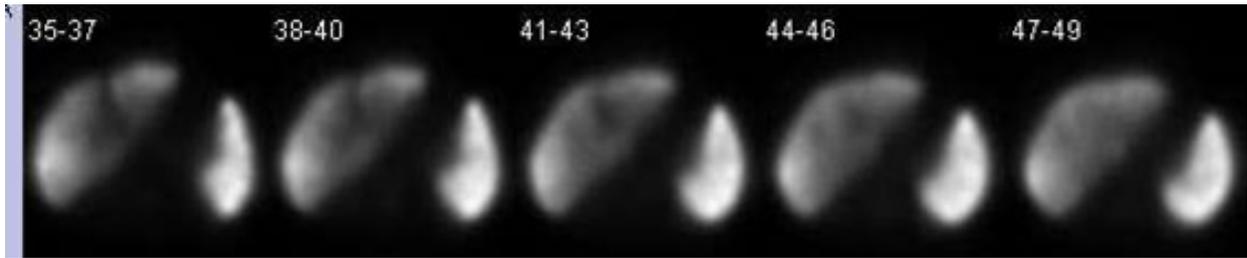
Transaxial SPECT images for a 66 year-old type 2 diabetic woman with hepatic fibrosis index 1.73 ( $> 0.65$  consistent with fibrosis) and Sn 2.52. Note evidence of portal hypertension with increased spleen concentration of tracer. Additional factors possibly contributing to hepatic fibrosis in this patient included history 18 months of breast cancer chemotherapy. Her FDG PET showed remission without liver or other metastasis. Patients with hepatic fibrosis have Sn  $2.66 \pm 1.5$ , comparable to patients with either severe type 2 DM (HbA1c  $10.9\% \pm 1.3\%$ ) or splenomegaly as shown in Fig 8B.
